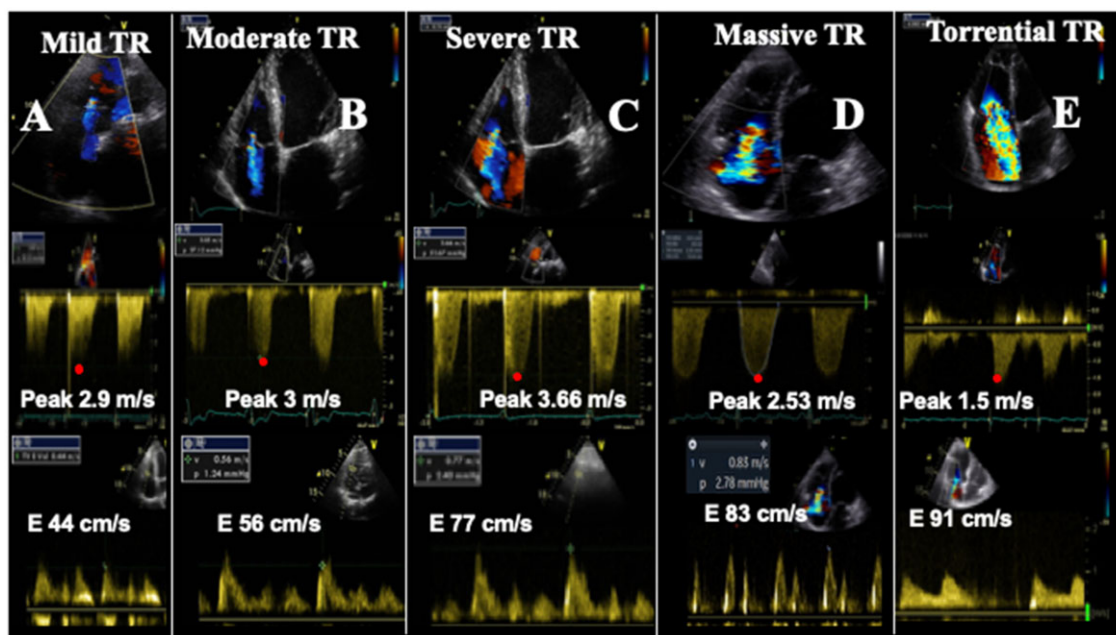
Five examples of various degrees of TR, mild (A), moderate (B), severe (C), massive (D), and torrential (E) are provided. The regurgitant jet area (RJA) as well as the tricuspid E wave velocity increase with the severity of TR. In severe TR, the continuous wave Doppler signal of the regurgitant jet is truncated, triangular and intense. The peak velocity of TR (continuous wave Doppler) allows the estimation of pulmonary pressure except in case of massive/torrential TR, since the Bernoulli equation is not applicable.
